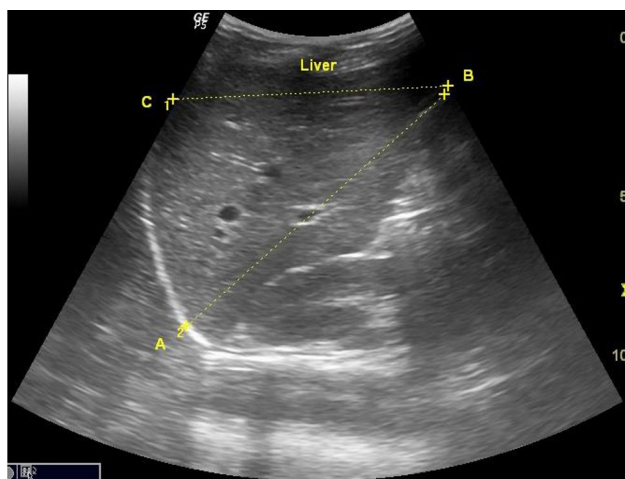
A B-mode longitudinal ultrasound image through the right lobe of the liver at the mid-clavicular line showing the liver and the right kidney. (BC = length of the right lobe of the liver)
